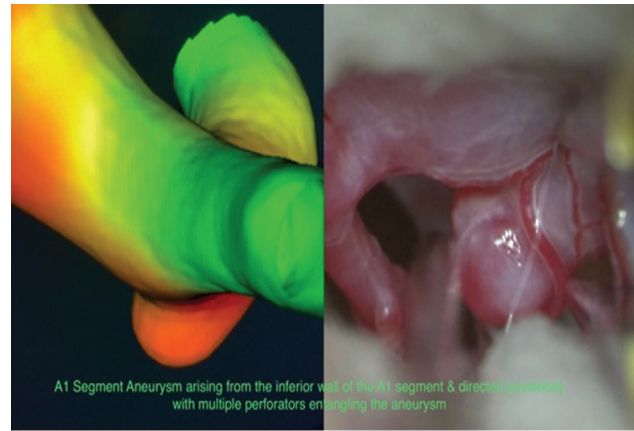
Three-dimensional computed tomography angiography of brain demonstrating an A1 segment aneurysm projecting posterior-inferiorly (green arrow).
